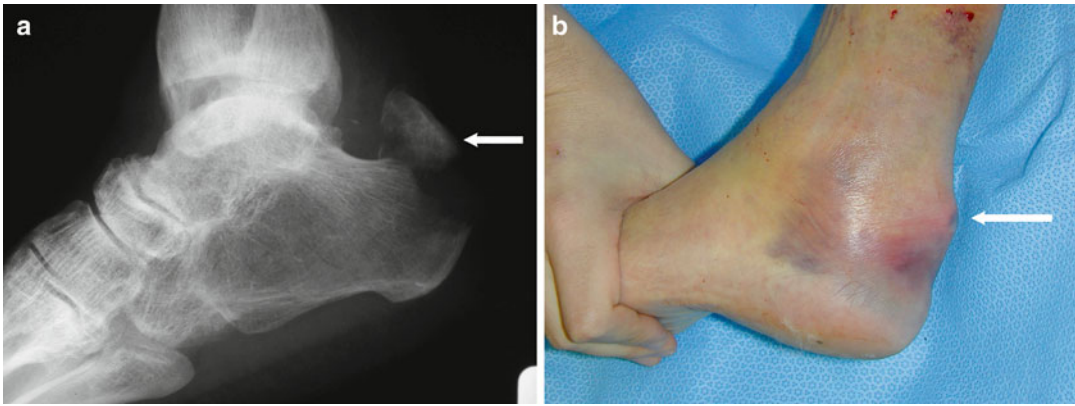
(a) Lateral radiograph showing avulsion fracture of the calcaneal tuberosity (*white arrow*) as seen in Brodsky type 3B Charcot arthropathy (b) Clinical view showing associated soft-tissue compromise (*white arrow*)
